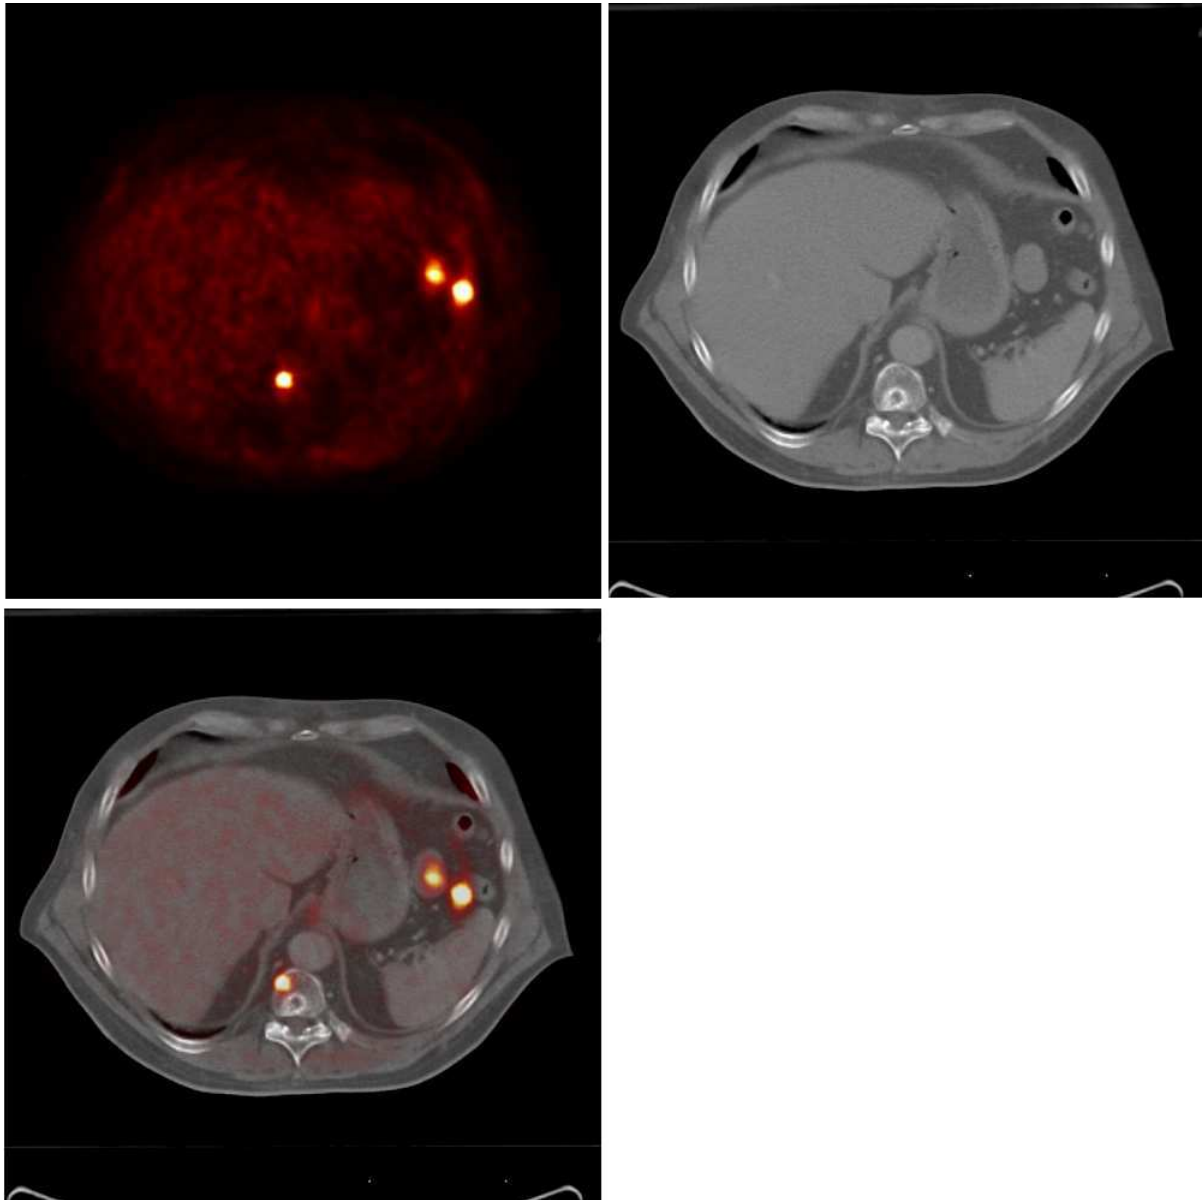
PET/CT. Top left: PET image, Top right: CT image. The fused image at bottom left shows both the metabolic information and the anatomic location of the lesion. Thus the exact location of the lesions becomes clear after fusion with the CT image.
